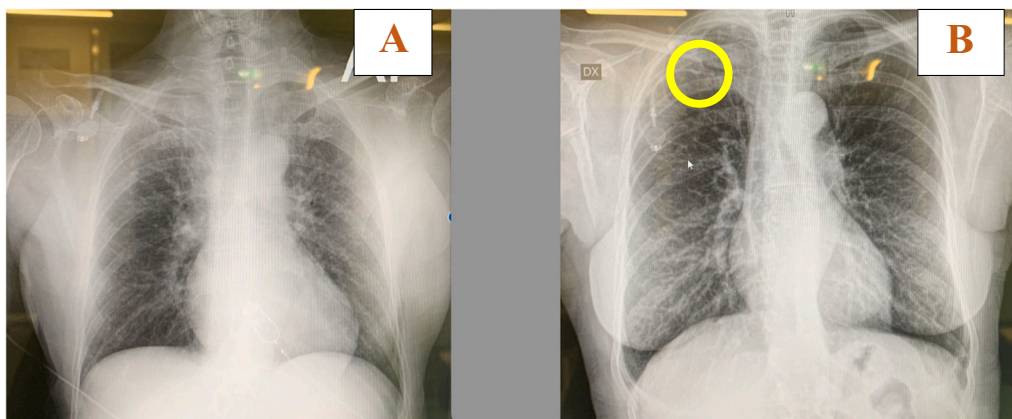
A. Control chest X-ray performed after placement of the port-a-cath in June 2021. B. Control chest X-ray showing catheter fragmentation at the first rib, January 2022.
